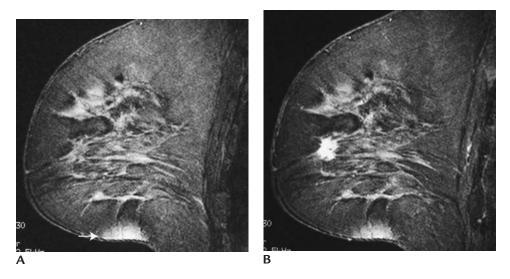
Invasive ductal carcinoma. (A) Sagittal, T1-weighted image pre-contrast. Bright coil artifact (*arrow*). (B) Sagittal, T1-weighted image immediately following contrast bolus. Rapidly enhancing irregular mass with spiculated margins.
